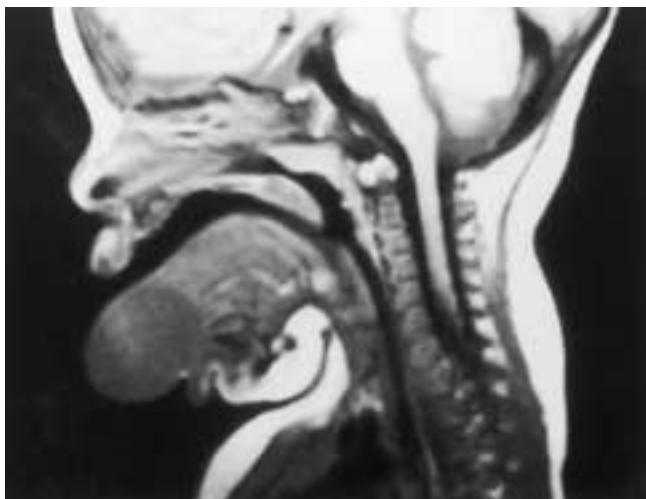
Intralingual ranula. Midsagittal T1-weighted image demonstrates a cystic lesion replacing the distal half of the oral tongue. The lesion is hypointense on T1-weighted images, and it became markedly hyperintense in a very homogeneous fashion on the heavily T2-weighted image (not shown), suggesting the fluid nature of the mass. (From Silverstein MI, Castillo M, Hudgins PA, et al. MR imaging of intralingual ranula in a child. *J Comput Assist Tomogr* 1990;14:672–673.)
